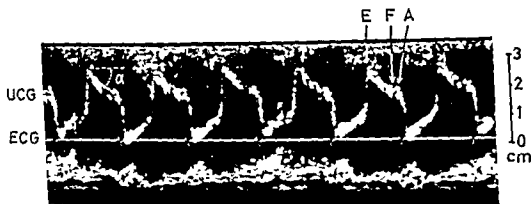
Ultrasonic cardiogram from the anteromedial mitral leaflet in mitral stenosis. The normally steep drop E to F is replaced by a slowly declining line throughout or during a major part of diastole. The angle α is a measure of the range of movement of the anteromedial mitral leaflet after the maximal opening of the mitral ostium early in ventricular diastole.
